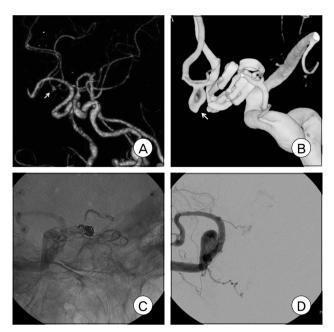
CT angiography performed ten days after surgery reveals the small, residual neck of the aneurysm (A). Angiography which was performed ten days after clipping shows slippage of clips from the aneurysm (B). Postembolization angiograms (C and D) reveals successful obliteration of the aneurysm.
